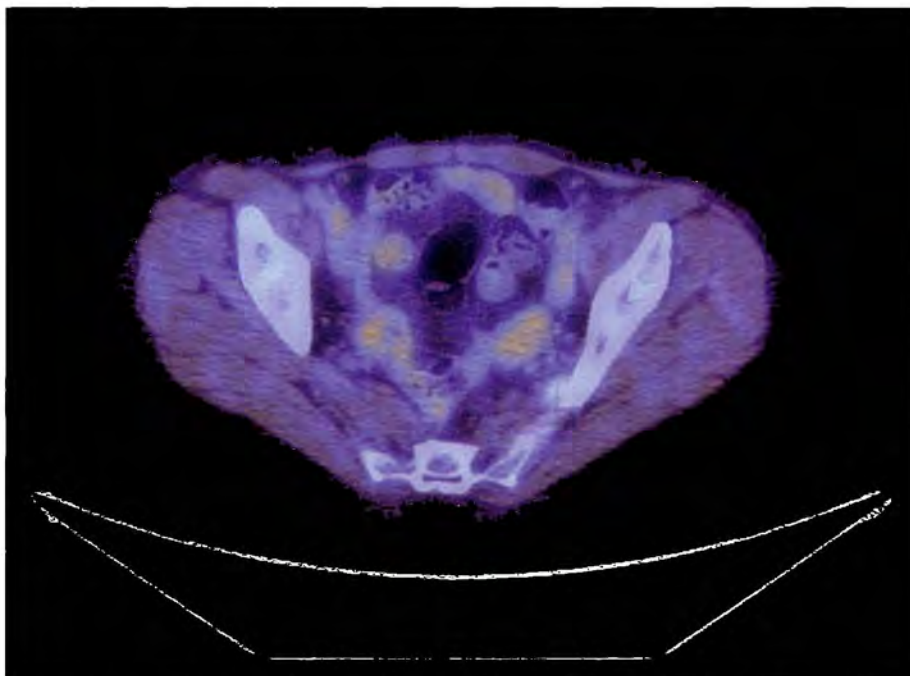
Follow-up positron emission tomography/computed tomography 10 weeks later reveals resolution of ovarian activity.
